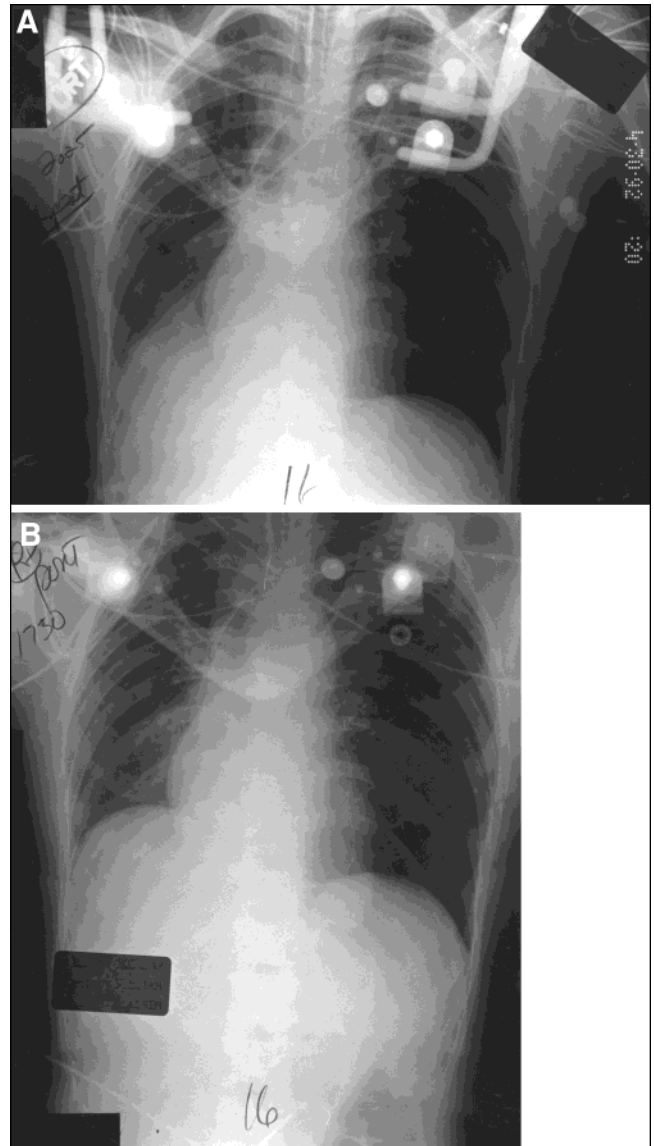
(A) A portable chest radiograph 1 h before pulmonary scintigraphy shows atelectasis of the right lower lobe, deviation of endotracheal tube to the right, elevation of the right hemidiaphragm, shifting the mediastinum to the right, an overexpanded left lung, and underexpanded right lung. (B) A chest radiograph obtained 4 h before pulmonary scintigraphy shows findings similar to those of Figure 2A except for less apparent atelectasis of the right lower lobe.
